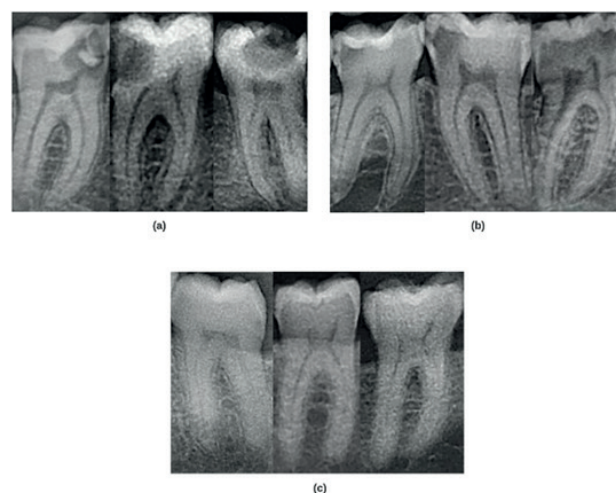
Examples of panoramic radiography images: (a) Endodontic, (b) Restorative, and (c) Healthy images.
